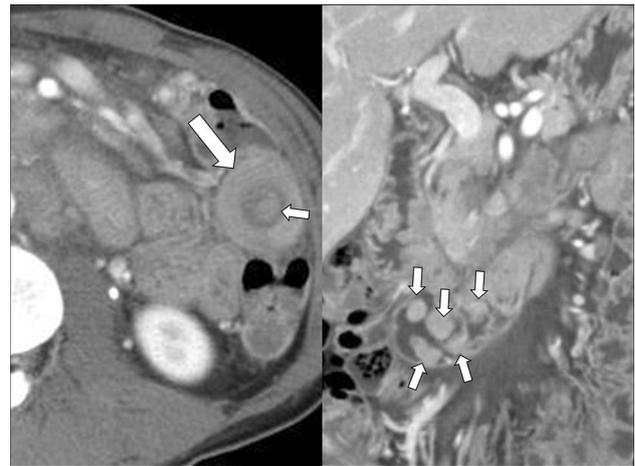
A 46-year-old man with small bowel obstruction by intussusception. Axial CT shows an enhancing, endoluminal polypoid mass (small arrow, left) with small bowel intussusception at the left abdomen (large arrow, left). Coronal CT shows multiple, small enhancing polyps in the jejunum (small arrows, right). This patient also had black pigmentation around the oral mucosa and lips. Pathology revealed hamartomatous polyps in the jejunum after surgery. The diagnosis of Peutz–Jeghers syndrome was made
